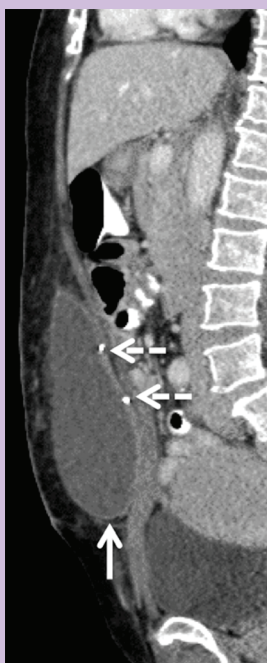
Sagittal CT image of the midline of the abdomen showing a seroma (arrow) occurring 3 weeks after abdominoplasty. Typical inward protrusion of the rectus muscles and surgical clips (dashed arrows) due to rectus plication are also depicted.
